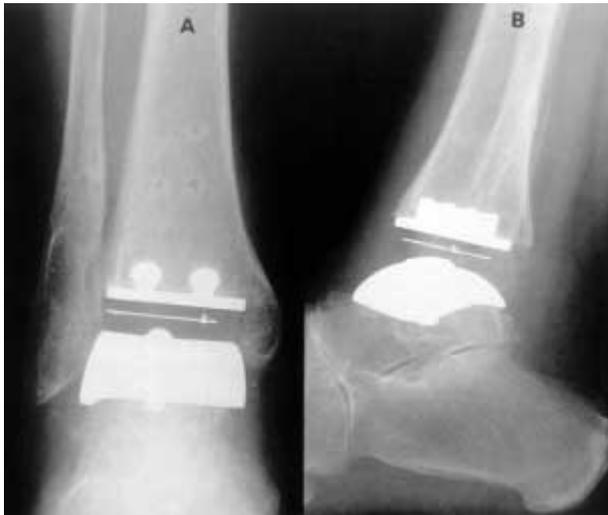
Radiographs of the right ankle of a male patient, 12 months after arthroplasty for post-traumatic degenerative changes: anterior view (a) and lateral view (b) showing optimal position of the STAR prosthesis.
